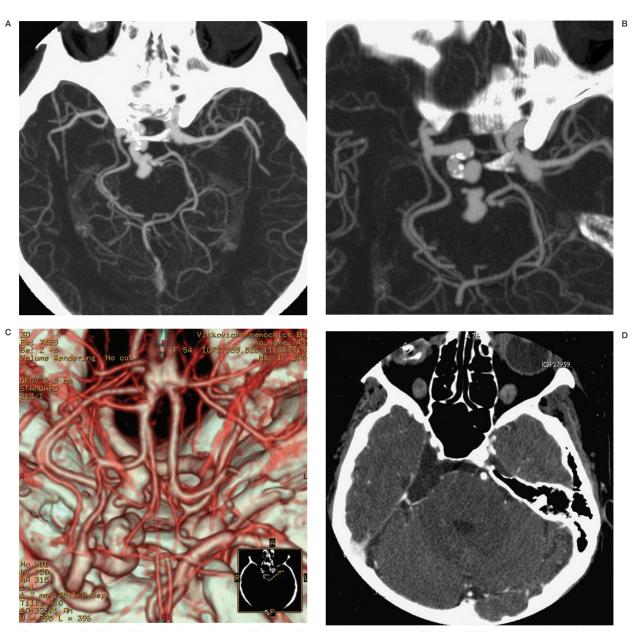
A,B) CTA MIP projections with calcified right PcomA with aneurysm. C) CTA VRT reconstructions with malformed C1 right supraclinoid segment, agenesis of the precommunicating right A1 segment. D) CTA source pictures-communicating arachnoid cyst at the right pyramind apex right pontocerebellar angle.
